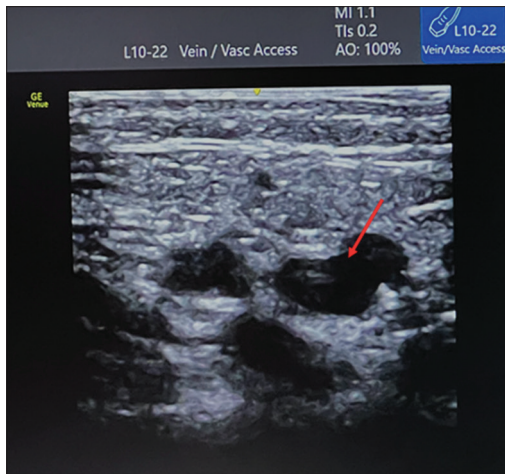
The narrow 24 Gauge needle with ultrasound/echogenic reflective scoring on its distal 4 mm that placed within the femoral vein using ultrasound guidance
